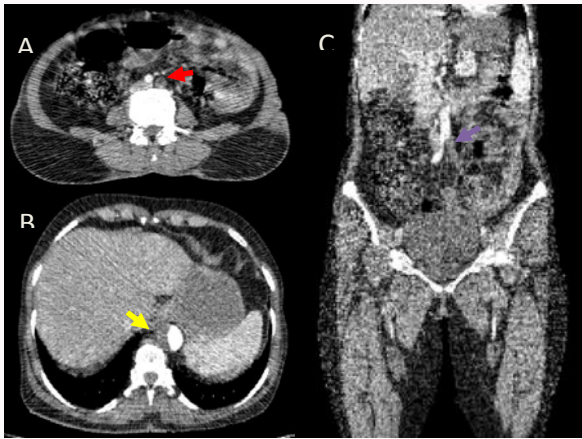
CT angiogram of the abdominal aorta shows evidence of eccentric hypodensity (yellow arrow in 1A) along the aortic lumen likely S/O dissection which is extending caudally across the bifurcation causing occlusion of the left common iliac artery (red arrow in 1B). Coronal reformat (1C) of the same shows occluded left common iliac artery (yellow arrow).
